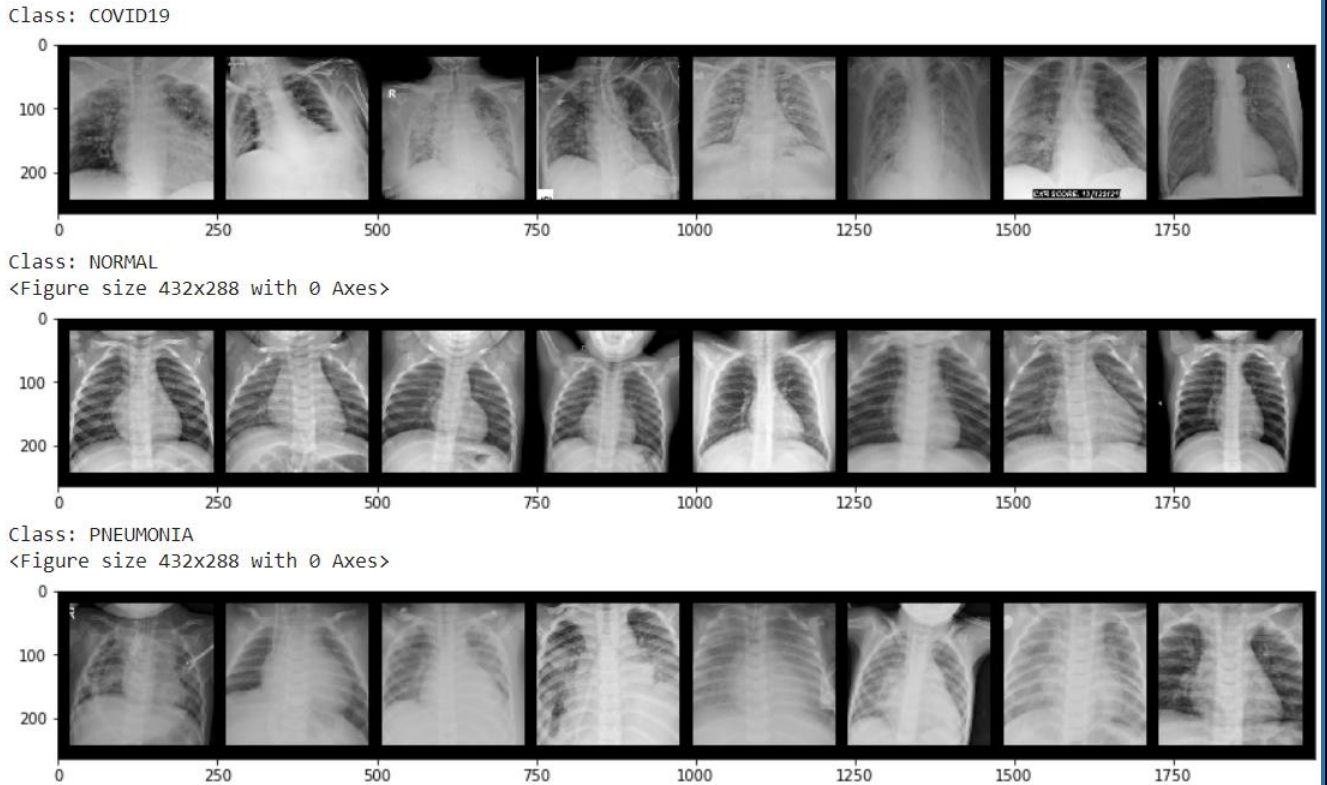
Representative chest X-ray images of COVID-19, pneumonia, and normal/healthy conditions. Note the increased ground glass opacity in COVID-19 X-ray images. Each image is of 224×224 resolutions.
